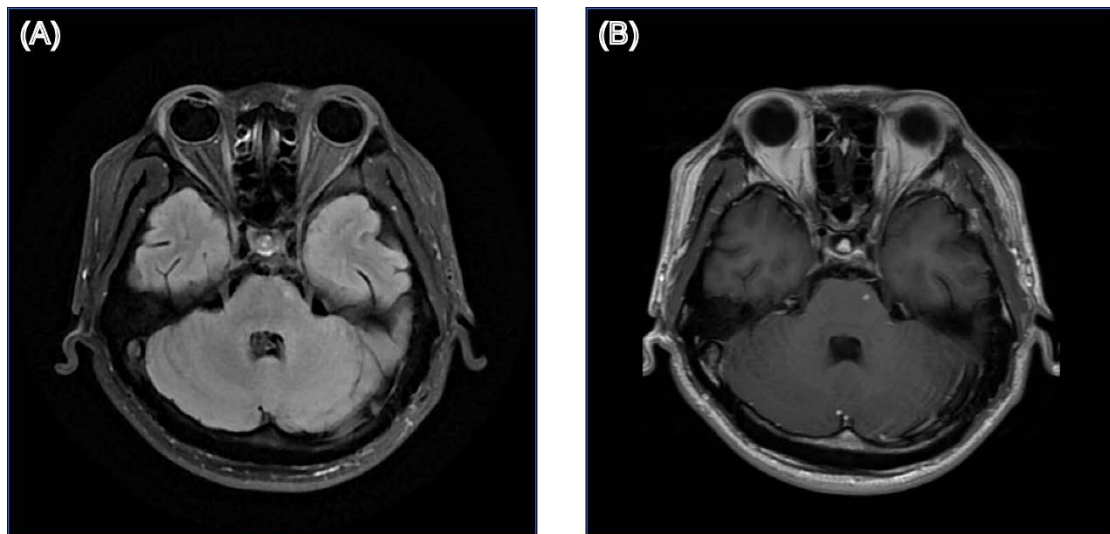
Structural brain MRI images of patient 06. (A) T2-weighted fluid-attenuated inversion recovery (T2-FLAIR) image; (B) Gadolinium-enhanced T1-weighted (Gd-T1w) image.
